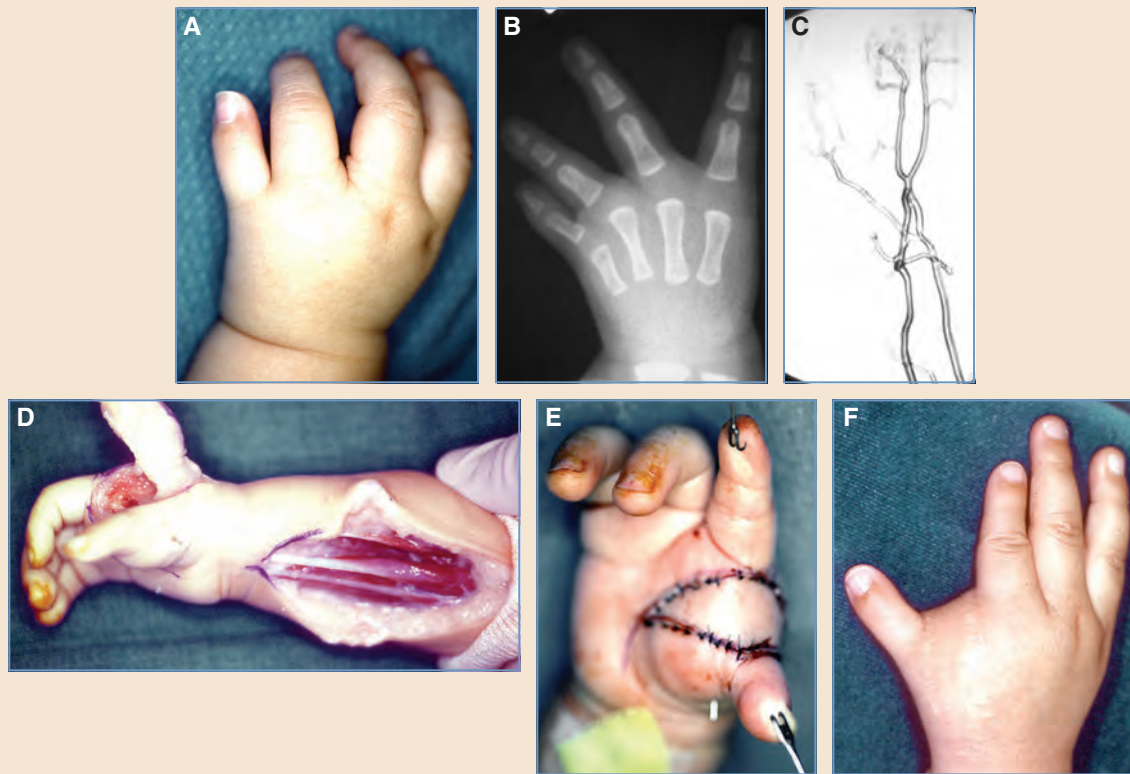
Type IIIA reconstruction with a radial forearm flap. A, Preoperative clinical appearance and radiograph showing a small thumb ray with an intact CMC joint and no first web space. B and C, The angiogram shows a three digits and one thumb hand with communication between the radial and ulnar portions of the hand. D, A distally based radial forearm vascular island flap has been passed through a generous subcutaneous tunnel into the defect created by release of the soft tissue between the thumb and index digits. This flap in young children contains a large amount of subcutaneous fat, which cannot be debrided. E, There is good perfusion after a tension-free inset into the new web space. F, One year later, the first web space has been well maintained by this full-thickness flap.
